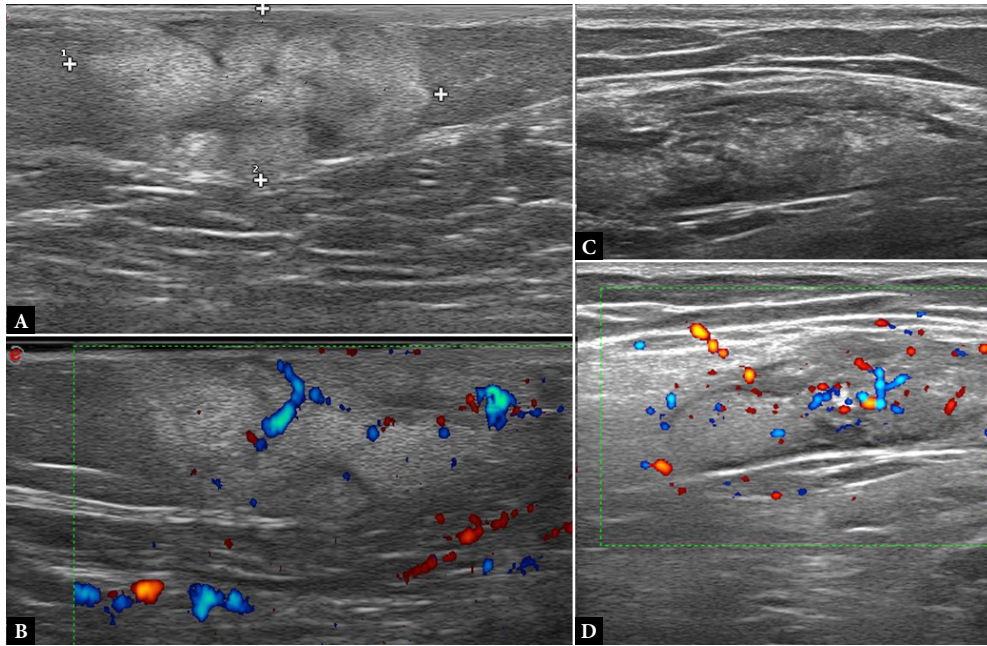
Malignant panniculitis: A, B. B-mode and Power Doppler images of a subcutaneous nodule in the posterior aspect of the right arm in a 47-year-old woman with lymphoblastic leukemia, showing a poorly marginated area in the subcutaneous tissue with increased volume and echogenicity, hypoechoic lines, and central and peripheral hyperemia; C, D. B-mode and Power Doppler images of a subcutaneous nodule in the posterior aspect of the right arm in a 41-year-old man with panniculitis-like T-cell lymphoma, showing a mixed panniculitis pattern involving the DSAT with chaotic vascular signals; the SSAT and dermis are spared
